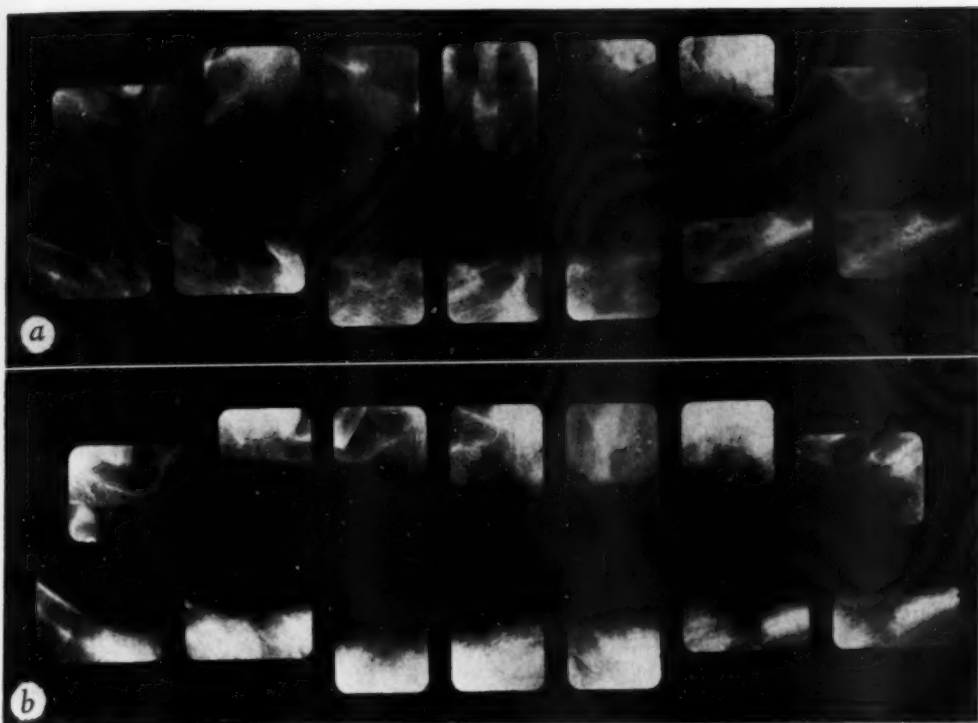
Hyperparathyroidism. *a*. Roentgenogram made prior to removal of a parathyroid adenoma, showing cystic spaces in the mandible which were occupied by giant-cell tumors. *b*. Roentgenogram made five and a half months after successful treatment. The cystic cavities formerly occupied by the tumors have been replaced by abnormally dense bone of increased radiographic density.
